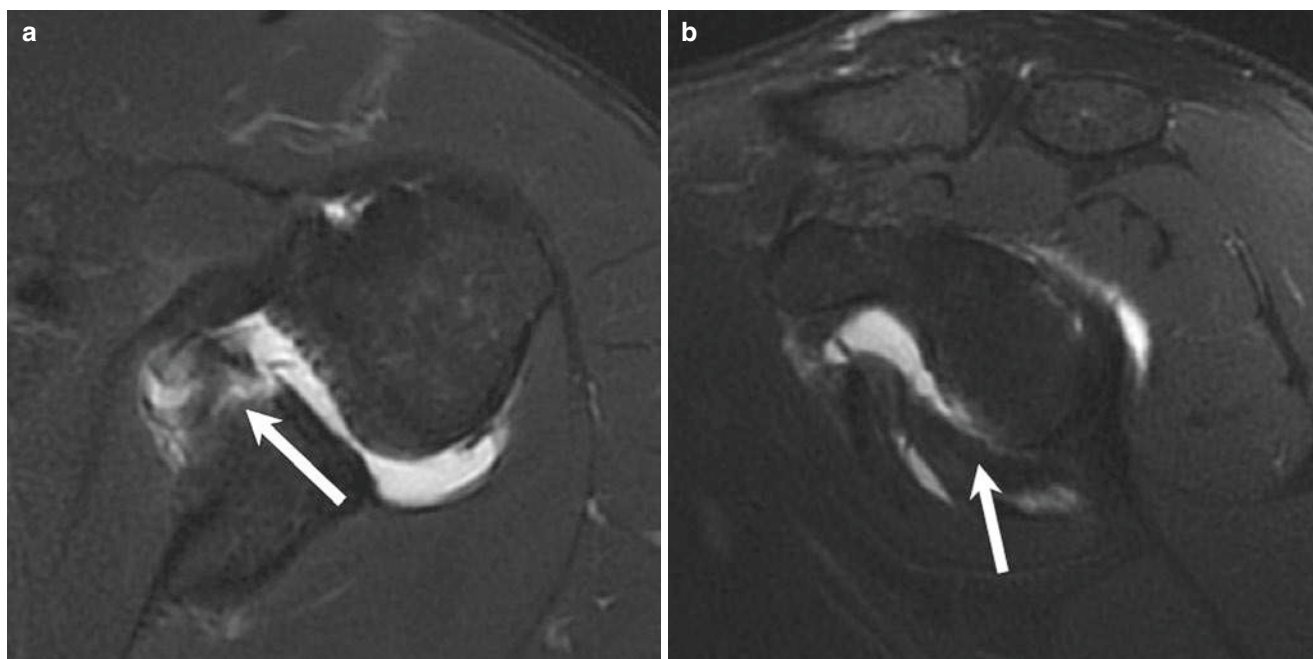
Bony Bankart lesion. Axial and sagittal fat-suppressed T1-weighted images demonstrate a bony Bankart lesion (*arrow*) with a fracture along the anteroinferior glenoid rim
